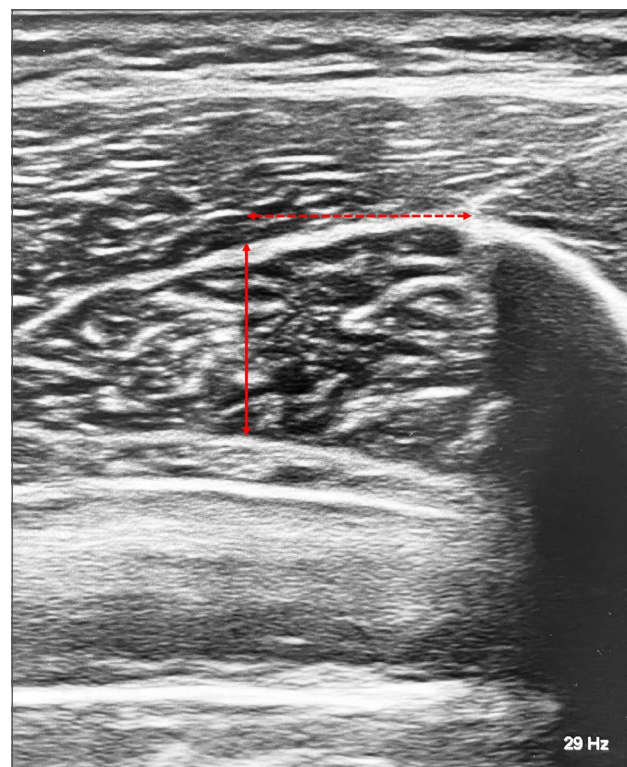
Dorsal ultrasound image showing TM thickness measurement (continuous line), acquired 1.5 cm (dashed line) from the scapular spine.
